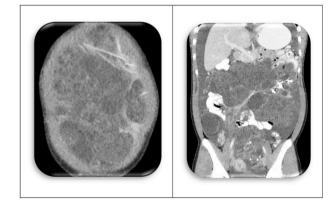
CT scan of Original Tumor.
